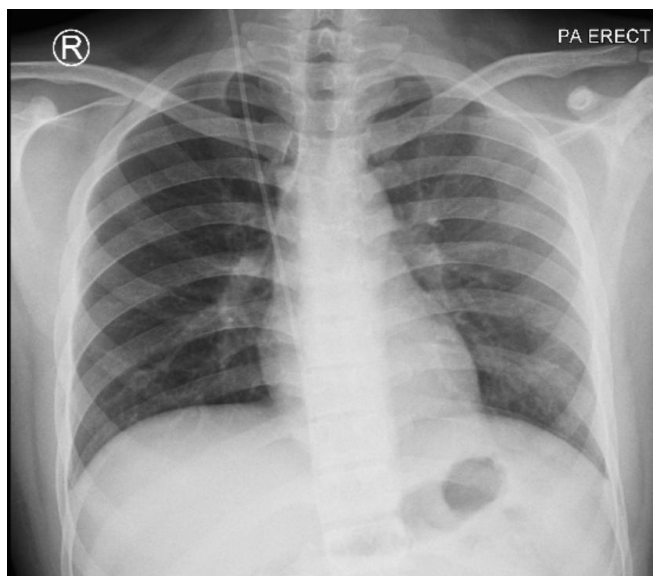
Normal chest X-ray findings with no cardiopulmonary abnormalities.
